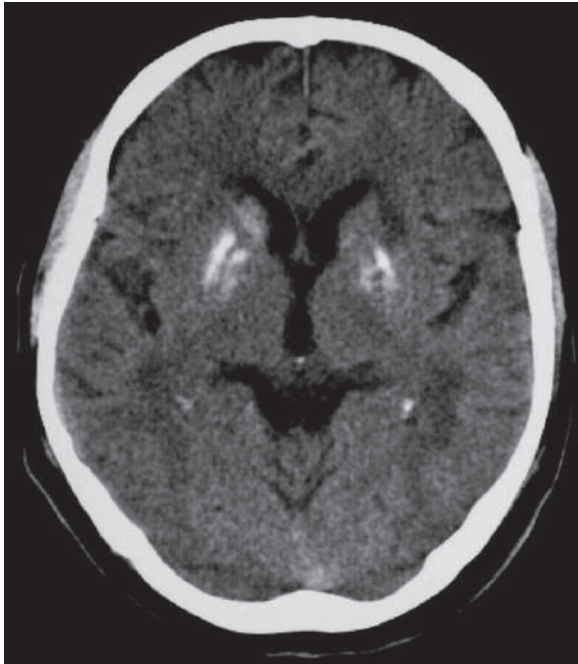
Axial nonenhanced brain CT shows bilateral, almost symmetrical, basal ganglia calcifications
